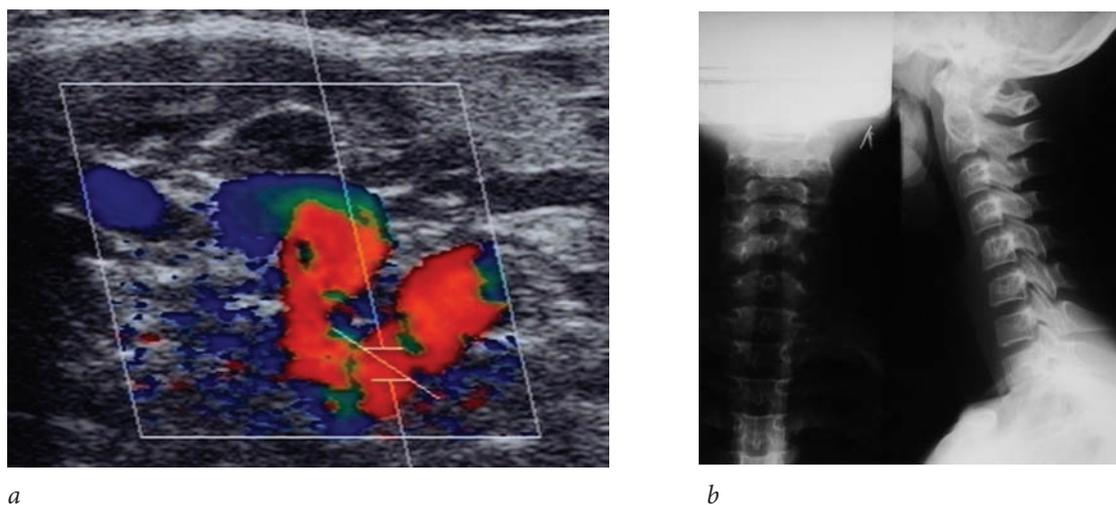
Patient K., 12 years old. Ultrasonogram of the congenital S-shaped deformity of segment V_1 of the vertebral artery (a) and X-ray images of the cervical spine in the anteroposterior and lateral views (b). The cervical lordosis is flattened; Kimmerle anomaly
